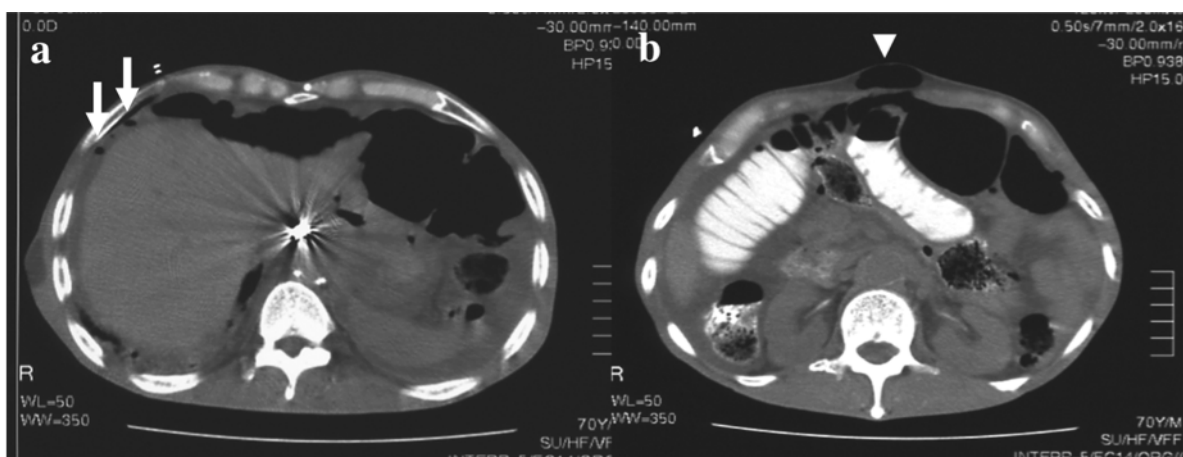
CT showed the dilated small intestine, with intra-abdominal free air at the liver surface (a white arrow) and in the sac of the incisional hernia (b, white arrow head), and ascites (a, b).
